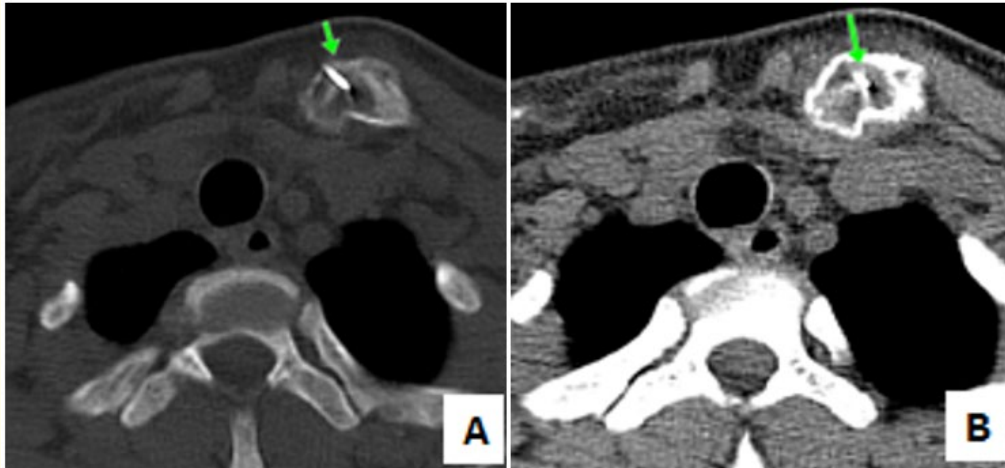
Axial-slice CT images in the bone window (A) and parenchymal window (B), passing at the level of the clavicle, showing the distal end of the trocar inside the lesion (green arrow).
